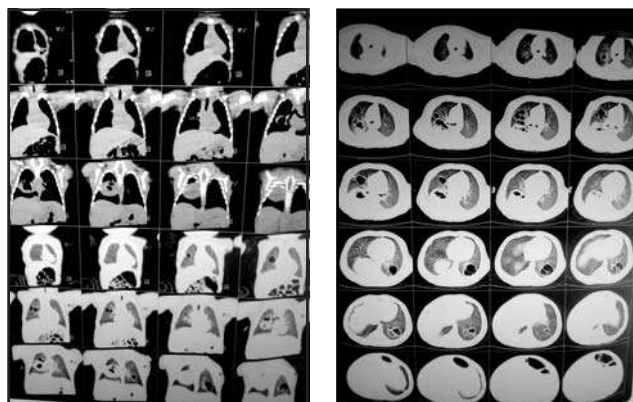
CT scan of chest showing multiple thick walled both macro and micro cystic lesion are seen in different segment of right lung and lower lobe of left lung.
